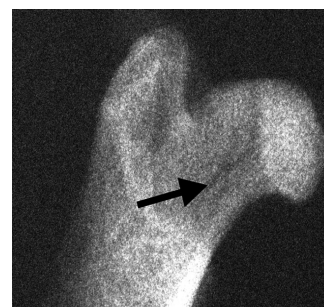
Detail of an X-ray image obtained after flexion-compression assay on the proximal third of left femurs, showing fracture (arrow).
